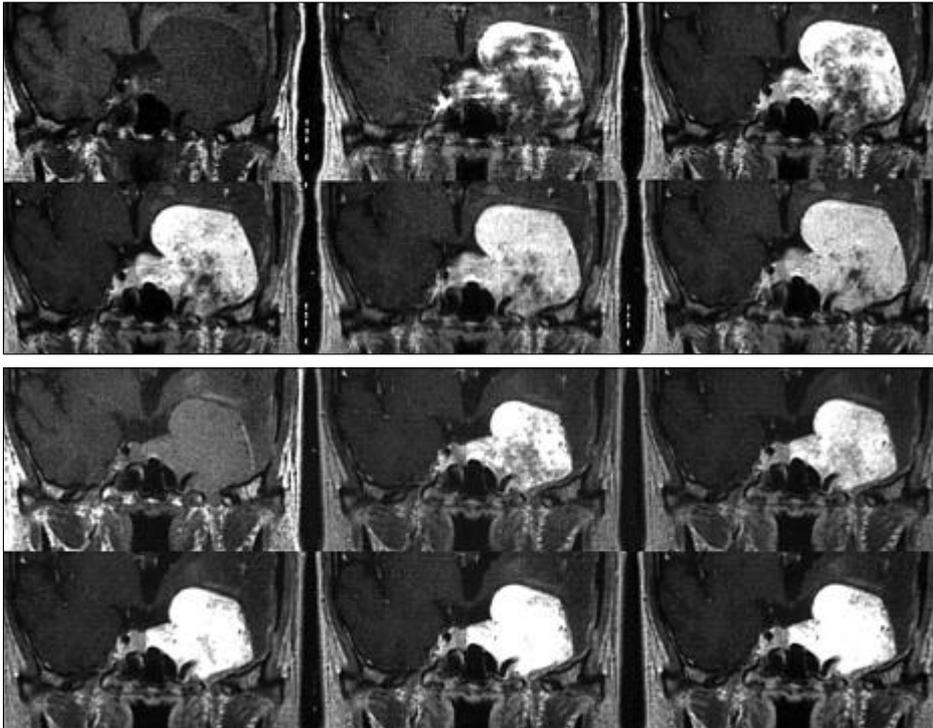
Traditional T1-weighted dynamic spin echo enhancement studies (TR/TE=300/17) with a one minute gap, before A and after radiotherapy B are shown. (A) Prior to irradiation, the dynamic images for the consecutive 5 minutes show an early and densely filling in the upper part of the tumor and a progressive delayed filling in the remaining portion. Relatively homogeneous enhancement is noted. (B) After irradiation, a more faster and denser filling of contrast than before radiotherapy is noted.
